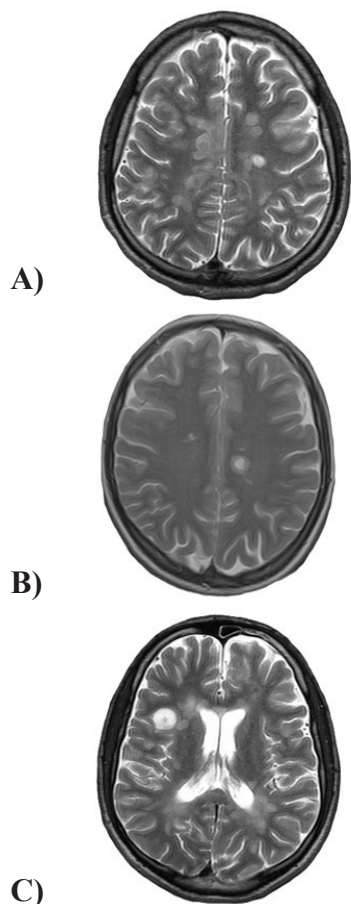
Brain MRI: A) axial FLAIR; B) T2-weighted sequences of paediatric patient with multiple sclerosis demonstrating multifocal hyperintense white matter lesions predominantly located in the periventricular and juxtacortical regions; C) Axial – T2 weighted sequences of paediatric patient with primary progressive multiple sclerosis demonstrating multifocal hyperintense white matter lesions predominantly located in the deep, juxtacortical, and periventricular regions
